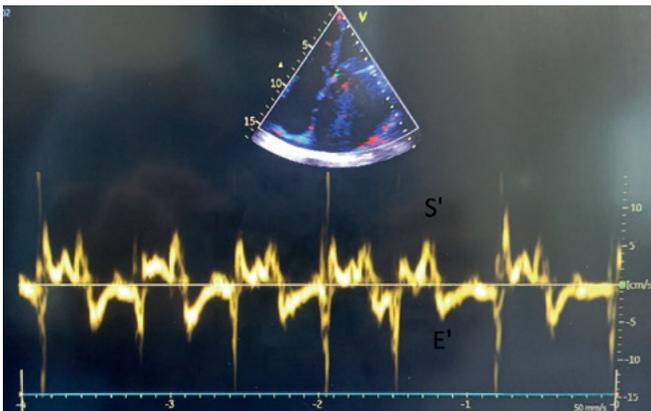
Assessment of peak annular plane velocities in systole and diastole in apical 4-chamber view by tissue Doppler velocity
